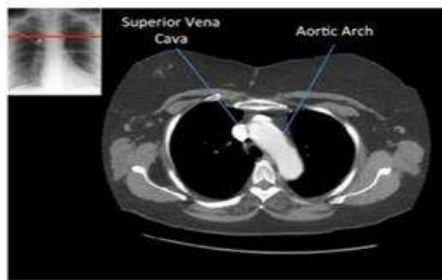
CT scans depicting anatomy at the level of the great vessels (*Whiting et al., 2015*).
